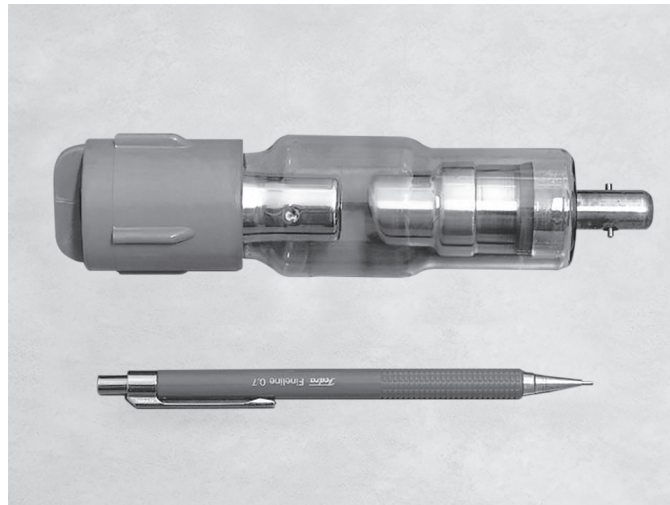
The X-ray tube (Source: Internet)
